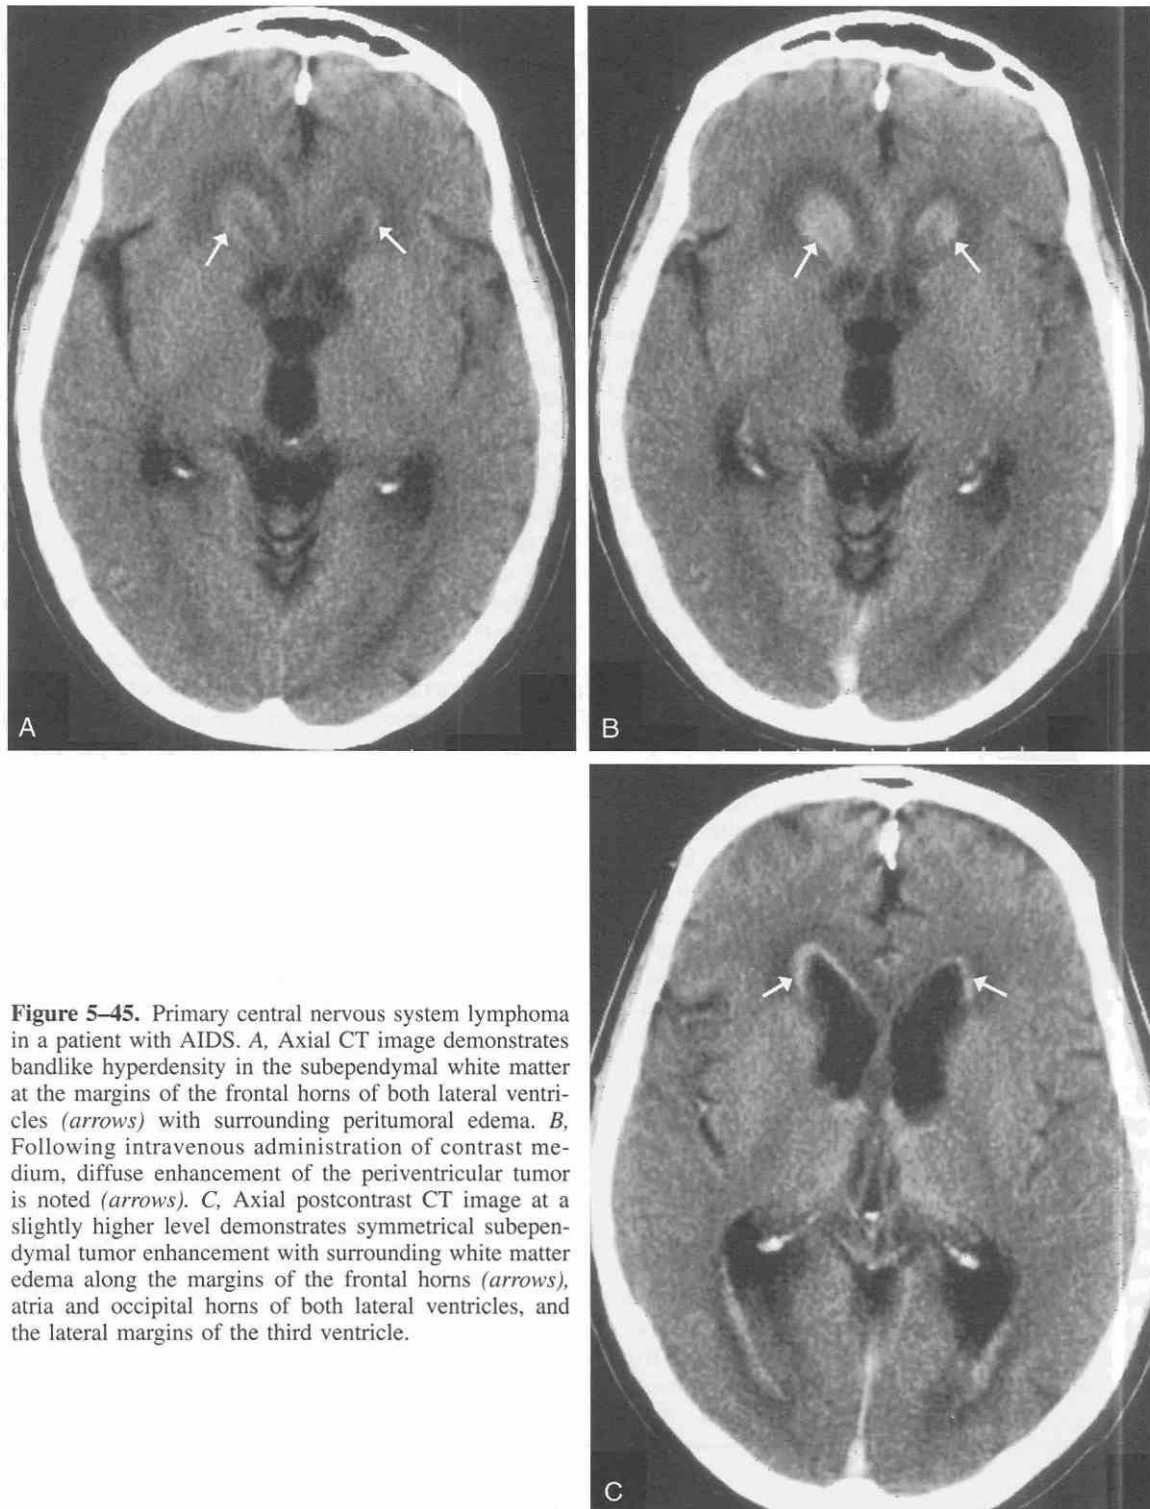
Primary central nervous system lymphoma in a patient with AIDS. *A*, Axial CT image demonstrates bandlike hyperdensity in the subependymal white matter at the margins of the frontal horns of both lateral ventricles (arrows) with surrounding peritumoral edema. *B*, Following intravenous administration of contrast medium, diffuse enhancement of the periventricular tumor is noted (arrows). *C*, Axial postcontrast CT image at a slightly higher level demonstrates symmetrical subependymal tumor enhancement with surrounding white matter edema along the margins of the frontal horns (arrows), atria and occipital horns of both lateral ventricles, and the lateral margins of the third ventricle.
